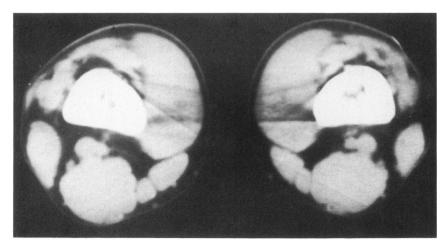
This 21-year-old student had a mass which was palpable in the left distal thigh when he was upright. CT scan with and without contrast material was normal.
